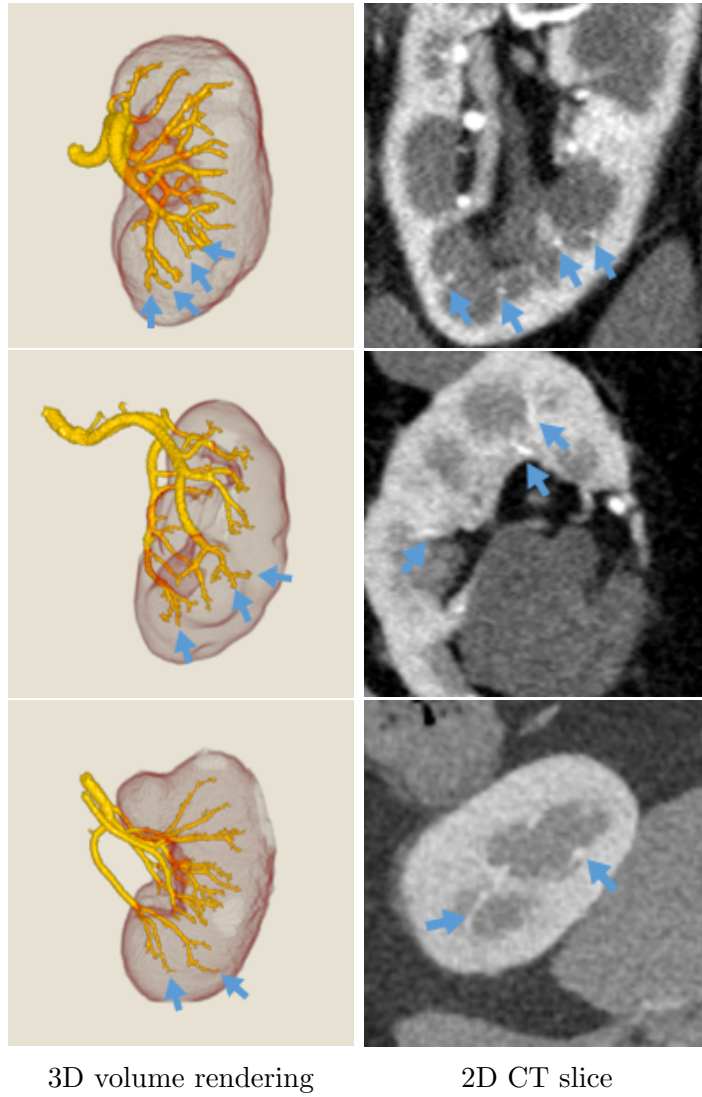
Segmentation performances on CT slices: Segmented tiny blood vessels are indicated by arrows on CT slices. These tiny renal arteries can be extracted by our proposed method.
